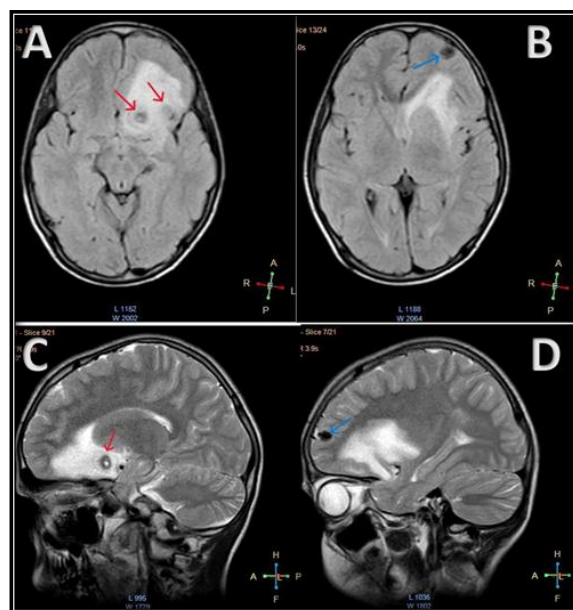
(case 4) Multiple colloid-vesicular stage of NCC seen on T2 (C) and FLAIR (A) with perilesional oedema. FLAIR (B) and T2 weighted image (D) showing calcified nodular stage of NCC.
